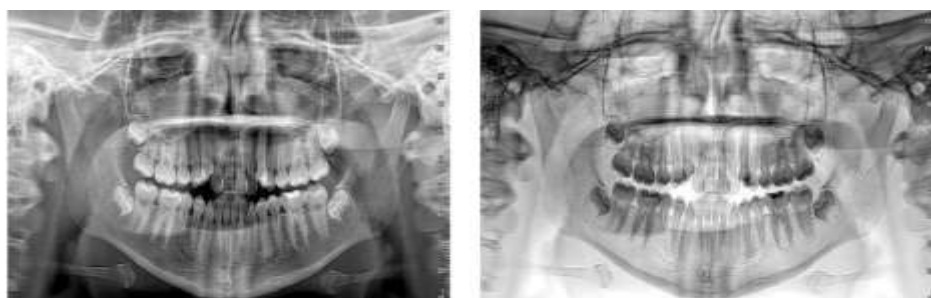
Panoramic radiograph showing the presence of the four third molar germs.
